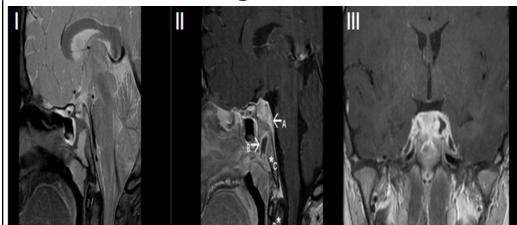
I: Sagittal fat-saturated Gd-enhanced T1-weighted MR image demonstrating fossa navicularis magna within the clivus. II: Sagittal T2-weighted MR image showing dural thickening (A) posterior to the clivus with associated enhancement. There is a rim-enhancing collection/abscess (B) within the canal in the body of the clivus. Enhancement of the marrow of the clivus (C) is greater than in the marrow elsewhere, e.g., of the odontoid process (D), in keeping with an associated osteomyelitis. III: Coronal MR image demonstrating involvement of the cavernous sinus.
